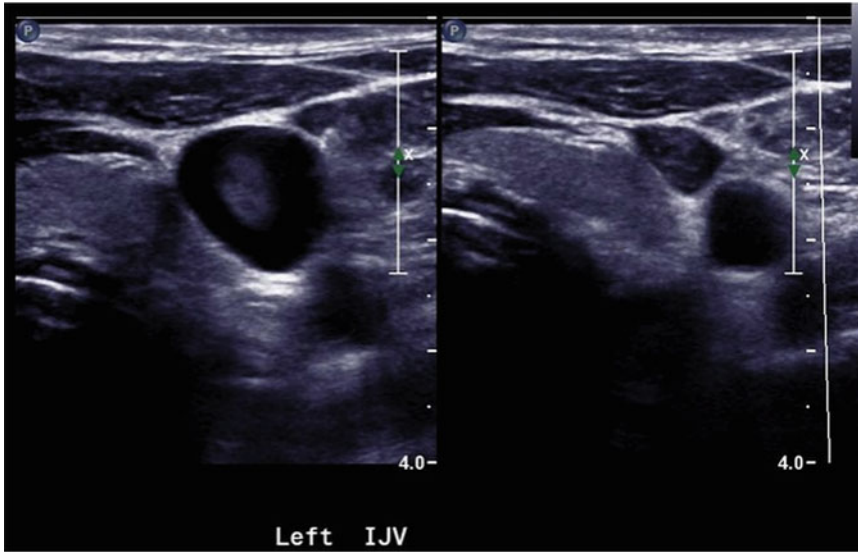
In the *left panel*, ultrasonography shows the internal jugular vein filled with echogenic thrombus. In the *right panel*, the vein walls do not coapt with compression
